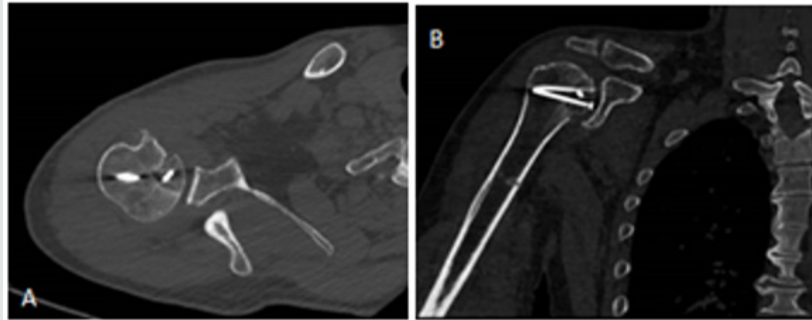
A-B: CT Scan 1-year follow-up.
